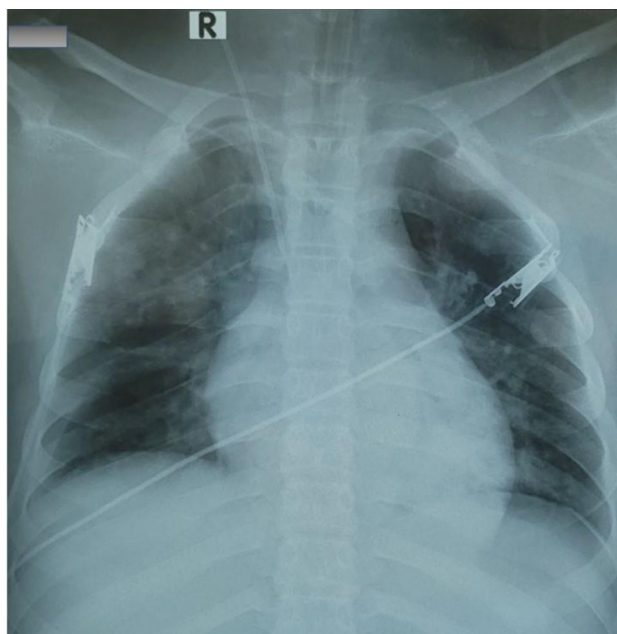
Chest x-ray imaging with pneumonia at admission. The presence of diffused and bilateral infiltration in lung parenchyma of reported patient with acute respiratory distress syndrome
